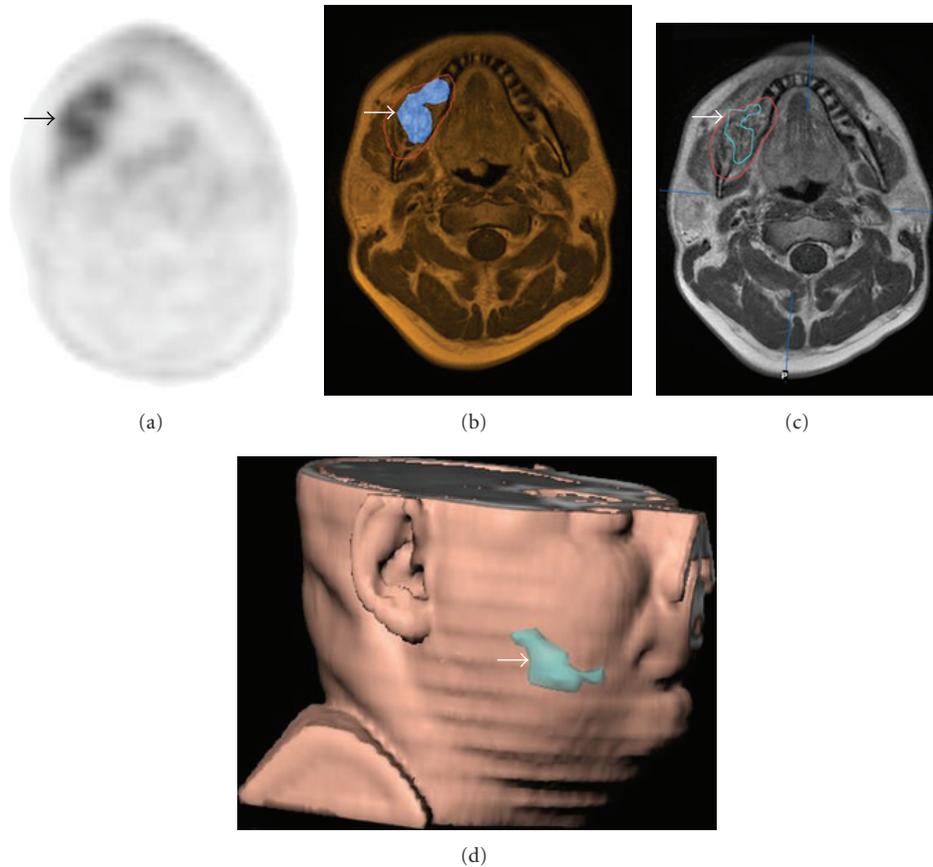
Patient with a squamous cell carcinoma of the right mandible (arrows). (a) The $[^{18}\text{F}]$ Galacto-RGD PET shows heterogeneous tracer uptake, which can also be clearly delineated in (b) the image fusion with the corresponding MRI scan. (c) shows the tumour volume in red as defined by MRI. By applying a threshold of SUV 3 and only using pixels with SUVs above this threshold, (d) a subvolume with more intense $\alpha\text{v}\beta 3$ expression can be defined which is shown in the 3D reconstruction (blue line in (c), blue area in (d)).
